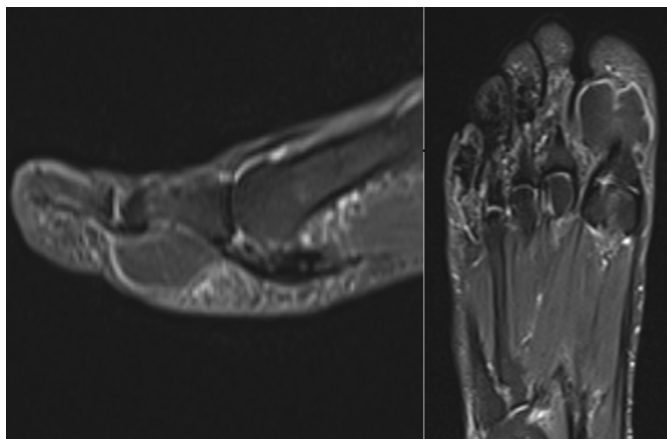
MR images of the mass located in the first toe of the right foot, T-2 sequence
